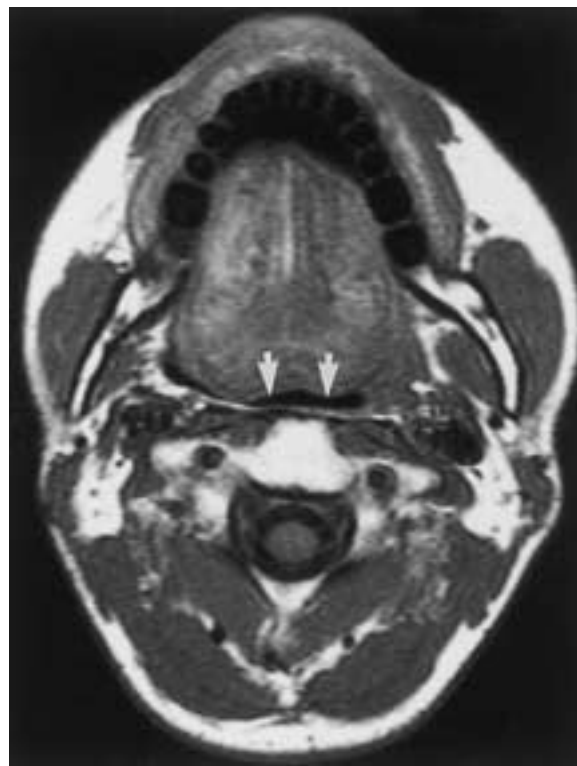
Radiation-induced oropharyngeal stenosis in a teenager who was irradiated as a child for rhabdomyosarcoma. Axial T1-weighted MR image reveals severe narrowing and asymmetry of the oropharynx (arrows).
